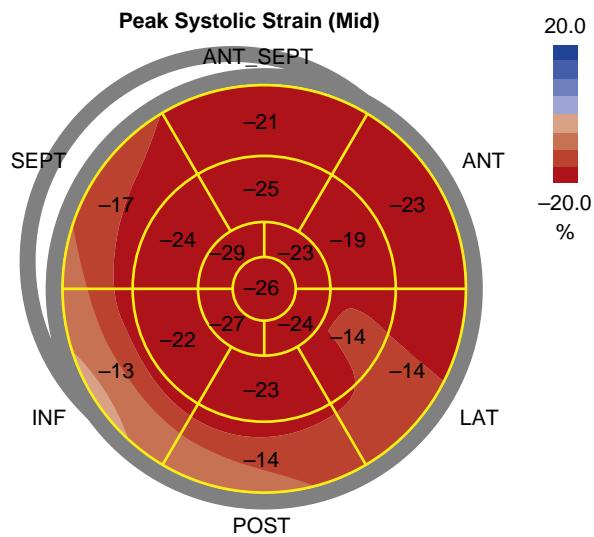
A transthoracic “bulls-eye” plot of speckle tracking-derived global longitudinal strain obtained with transthoracic echocardiography. The image depicts the 17 segments of the left ventricle and the peak segmental systolic strain for each segment. The dark red areas represent normal strain, while the light red and pink areas represent abnormal strain. The average global longitudinal strain in this example is normal (-20.8% , not displayed in the image).
